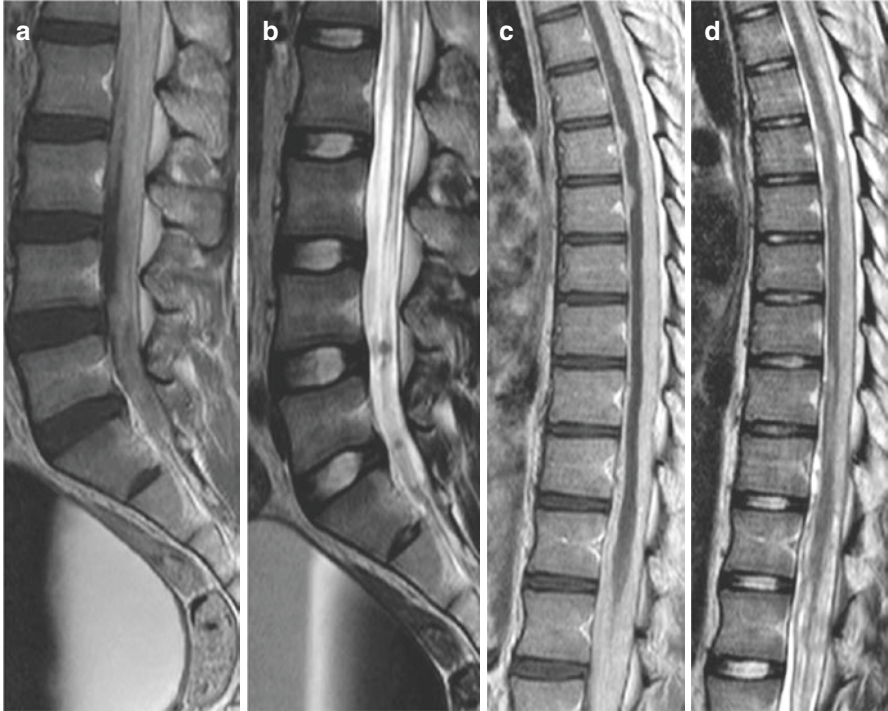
Intradural disease and arachnoiditis. Sagittal T2 (a, c) and T1 post contrast (b, d) MRI demonstrate intradural enhancing material and lower down focal nodularity and clumping of the cauda equina nerve roots compatible with arachnoiditis
